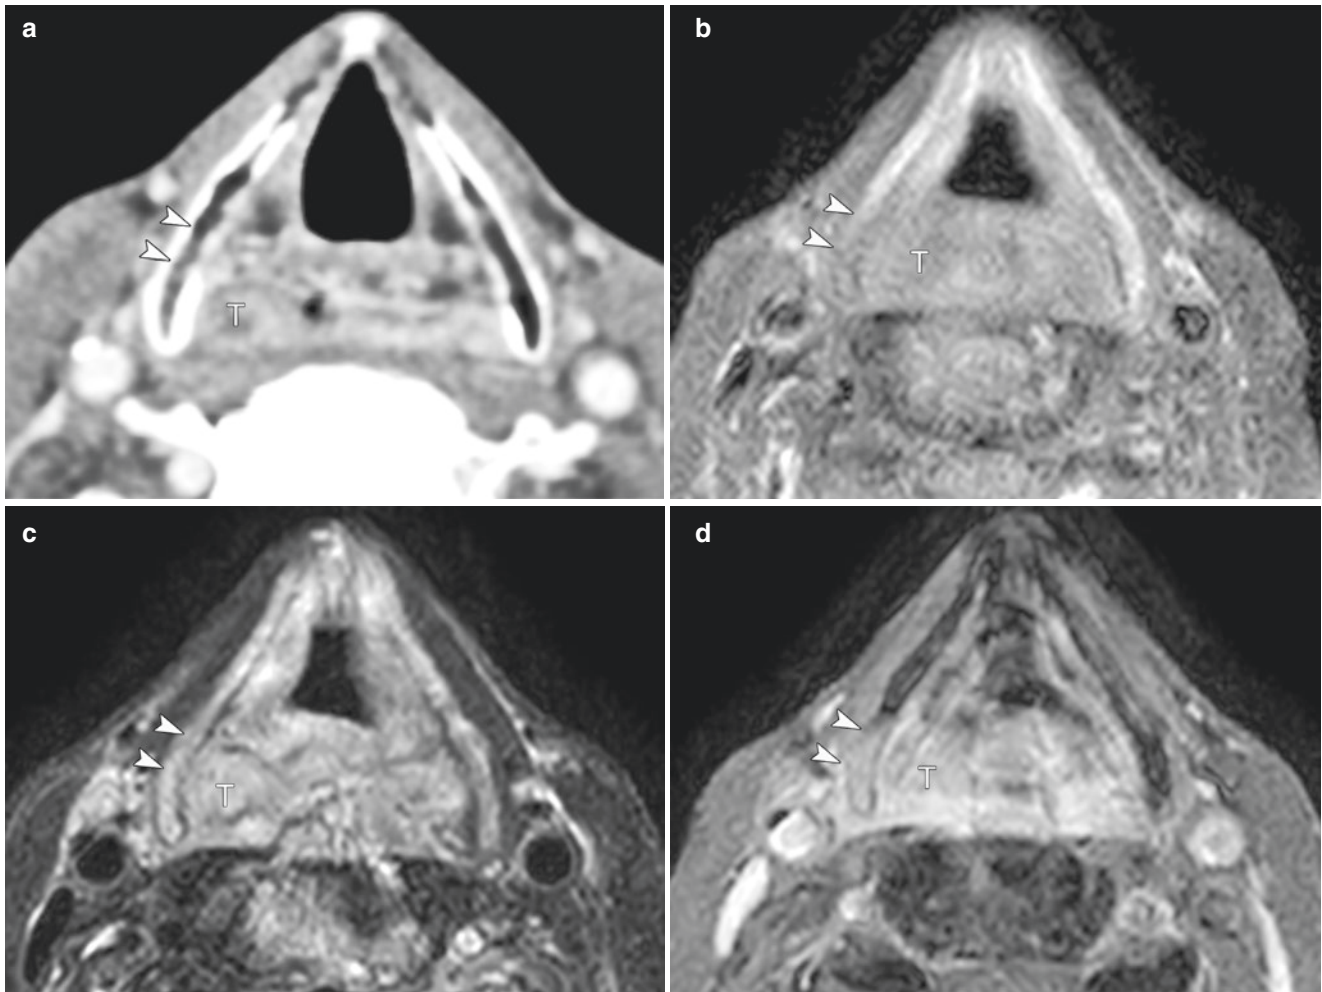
False-positive findings for thyroid cartilage invasion on MR imaging with hypopharyngeal cancer. Contrast-enhanced CT image at the false vocal cord level shows a tumor (T) arising from the right pyriform sinus without erosion or lysis at the thyroid cartilage. T1-weighted image shows that the tumor (T) has low signal intensity, whereas adjacent thyroid cartilage has similar signal intensity (arrowheads). On T2-weighted MR image (c), the adjacent posterior right thyroid lamina
